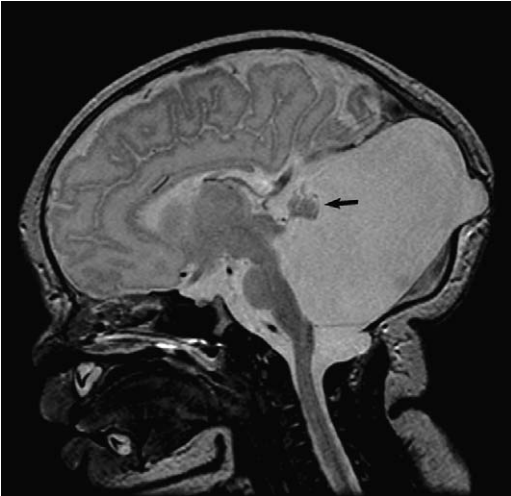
Dandy-Walker malformation. Sagittal T2-weighted image demonstrates the classic features of a Dandy-Walker malformation. The vermis is severely hypoplastic (*arrow*). The fourth ventricle is “open,” communicating with a large retrocerebellar cyst. The posterior fossa is enlarged with torcular-lambdoidal inversion. Note the small occipital meningocele, a common association with Dandy-Walker malformations.
